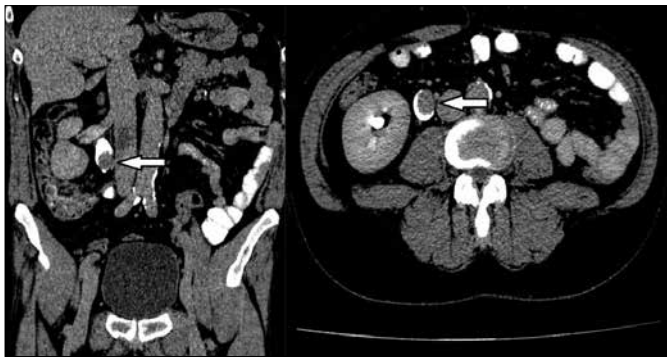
CT-scan in urographic phase. The arrow indicates a tumor.
